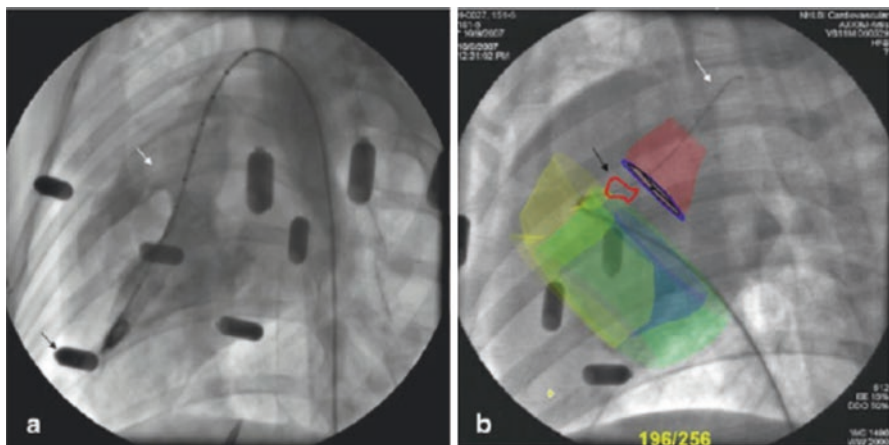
Interventional MRI and angiographic fusion. Interventional applications of MRI allow real-time fusion of angiographic and MRI images in hybrid MRI/angiosuites for direct procedural guidance. (Image courtesy of Dr. Lederman; adapted with permission from Ratnayaka et al. [74])
